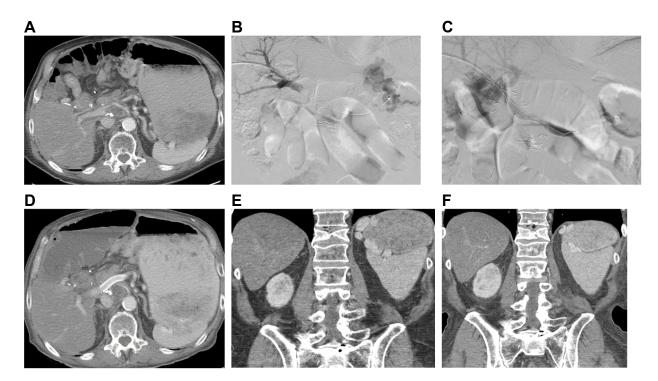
77-year-old man with recurrent pancreatic cancer after Whipple, with tumor in the portal and splenic veins, causing sinistral portal hypertension and bleeding gastric varices. (A) CT shows tumor occluding the portal/splenic vein. (B) Simultaneous portal and splenic venograms show complete occlusion of the splenic vein extending to the main portal vein, with filling of gastric varices. (C) After portal vein stent placement, venogram shows good hepatopetal flow from the splenic vein through the stent into the portal vein, with no filling of gastric varices. (D) CT image 1 month after stent placement, showing a patent portal vein stent. (E) & (F) Coronal CT images before and 4 months after portal vein stenting, showing interval decrease in gastric varices.
